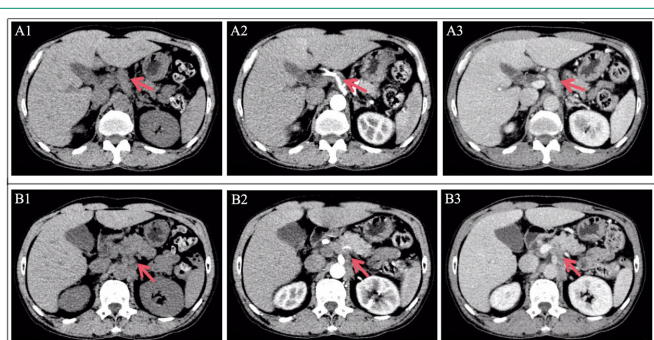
Plain and enhanced CT images of this patient (red arrow indicating the lesion). (A1-A3 and B1-B3) Axial CT images of non-contrast scanning, arterial phase and venous phase of enhancement, respectively, show a strip-shaped soft tissue around the coeliac artery with mild enhancement.
